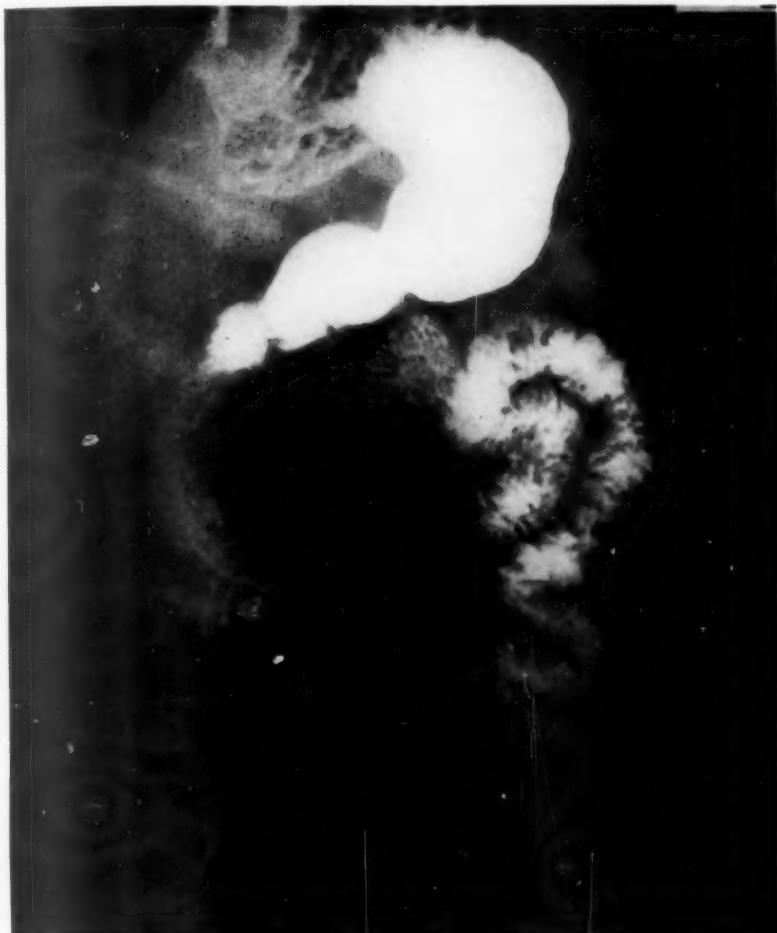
Roentgenogram showing tumor of duodenum.
